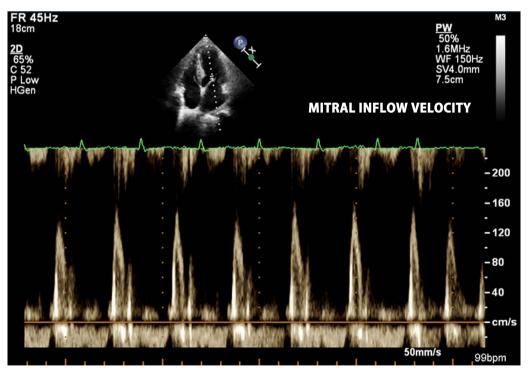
Echocardiography showing mitral inflow velocity with no significant respiratory inflow variation.
